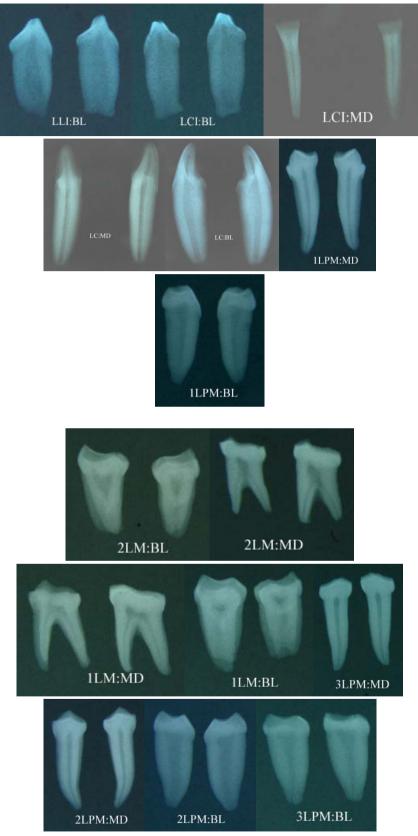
Periapical radiographic of mandible teeth (Linnaeus, 1758).
